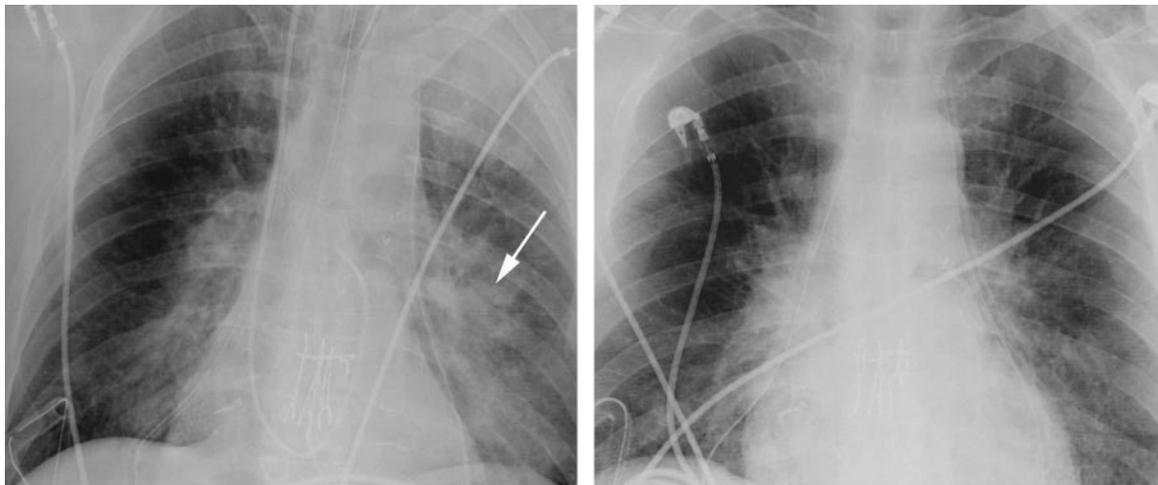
Ischemia-reperfusion injury in a patient with bilateral lung transplants for idiopathic pulmonary hypertension. (a) Chest radiograph, obtained 24 hours after lung transplantation, demonstrates bilateral lower-lobe heterogeneous airspace opacities (arrow) with peribronchovascular thickening. (b) Chest radiograph, obtained more than 48 hours after transplantation, demonstrates interval resolution. Although the findings are nonspecific, the temporal relationship with regard to lung transplantation and the rapid resolution of the abnormal radiographic features are suggestive of this diagnosis.
